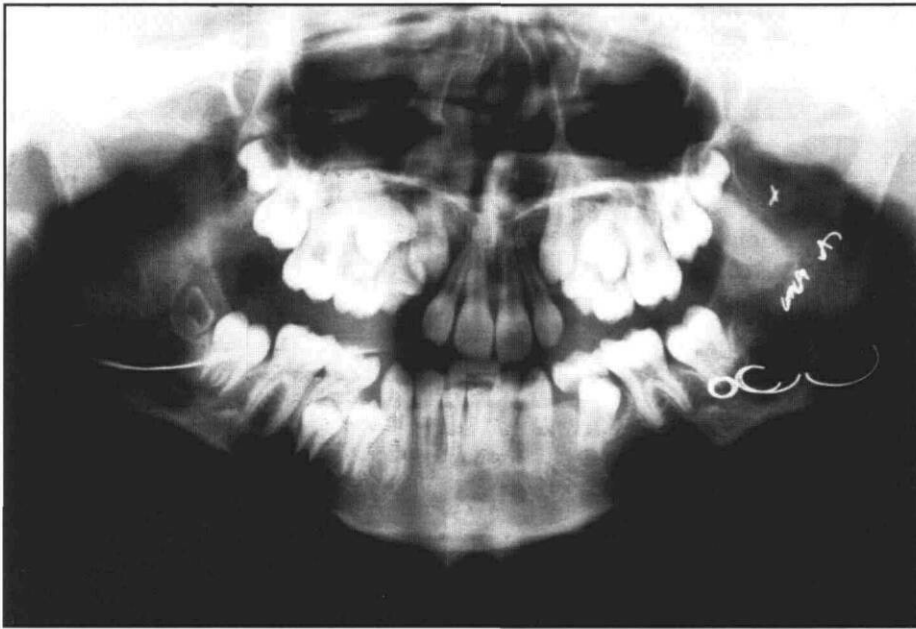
Two-year postoperative panoramic radiograph showing apparent bony fill of the surgitized area.
